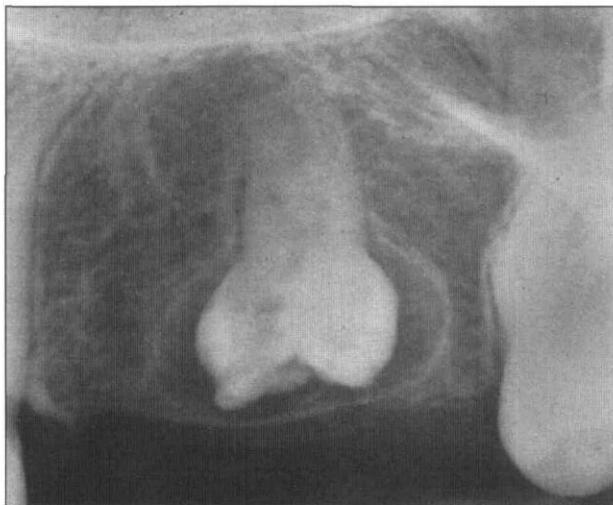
Intraoral radiograph of 12 in Case 1.
